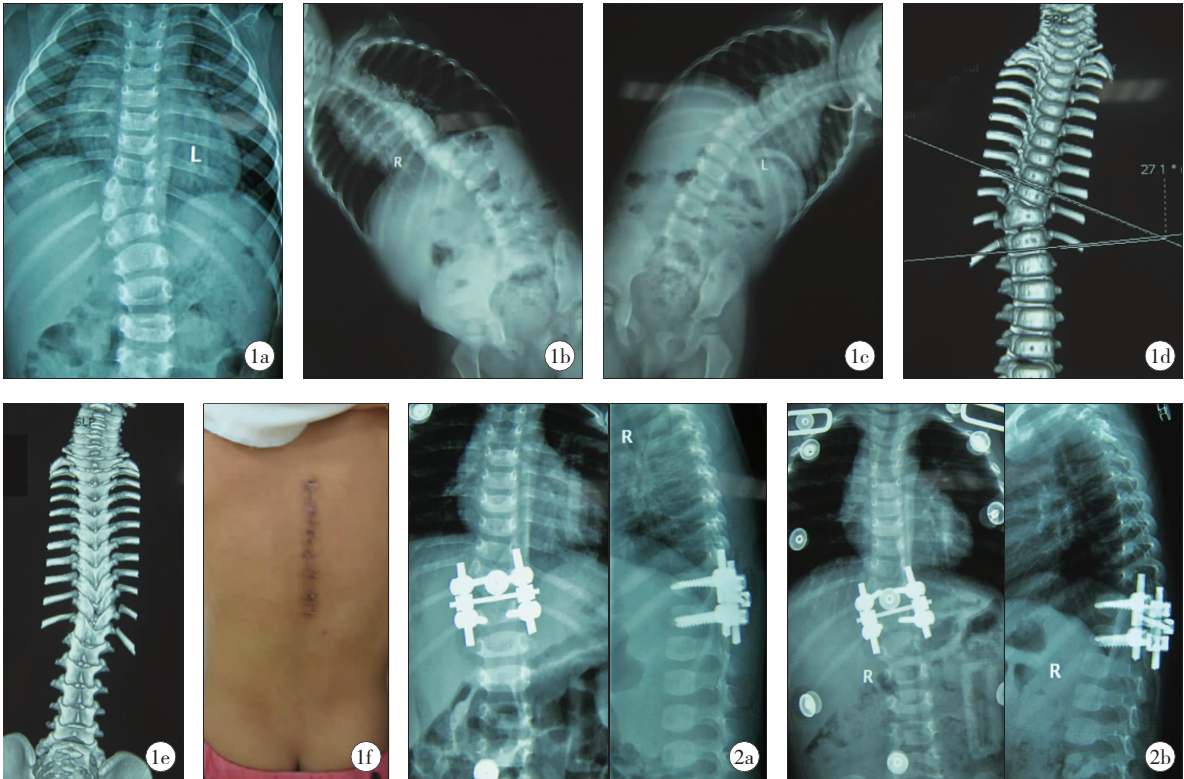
患儿术前 X 线正位片及左右板正像:a,先天性胸 11 半椎体;b、c,左右板正像提示脊柱弯曲度良好,d、e、f 提示三维 CT 重建及术后恢复外观; 图 2 术后 7 d X 线正侧位片,a,半椎体完全切除,椎弓根螺钉固定上下两个椎体,Cobb's 角恢复满意,b,术后 3 个月患儿佩戴支具矫正代偿性侧弯,效果满意。
